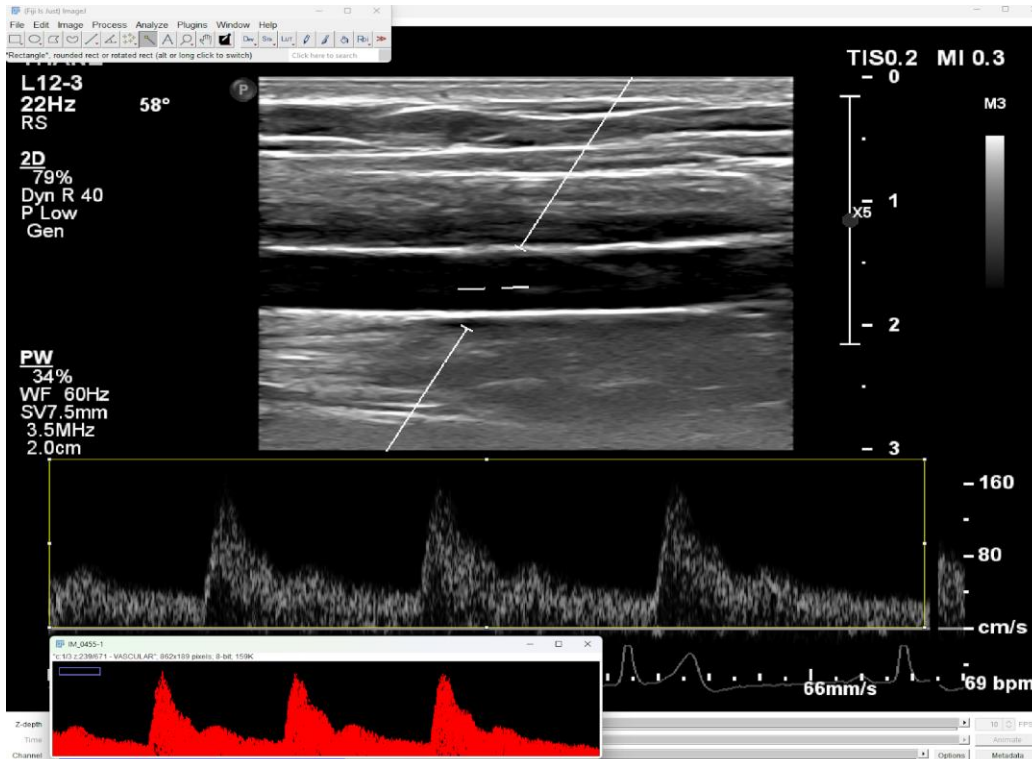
Example of thresholding of the doppler ROI within Fiji showing the sample video and a selected and cropped region for analysis.
